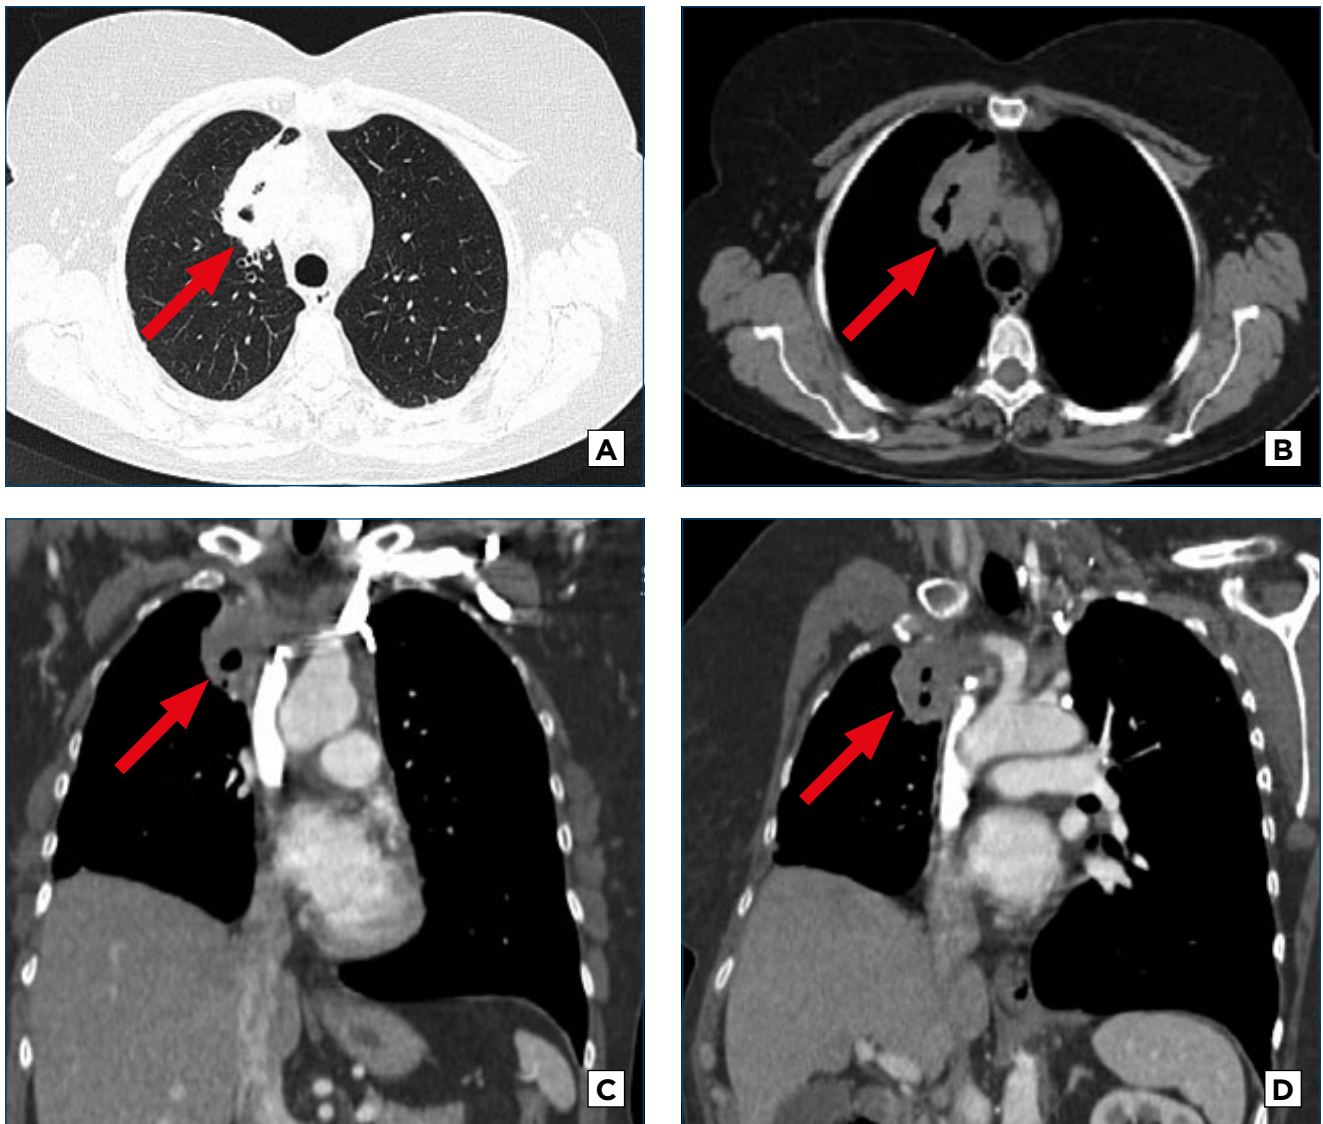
Thoracic CT scan with contrast medium - November 2013
